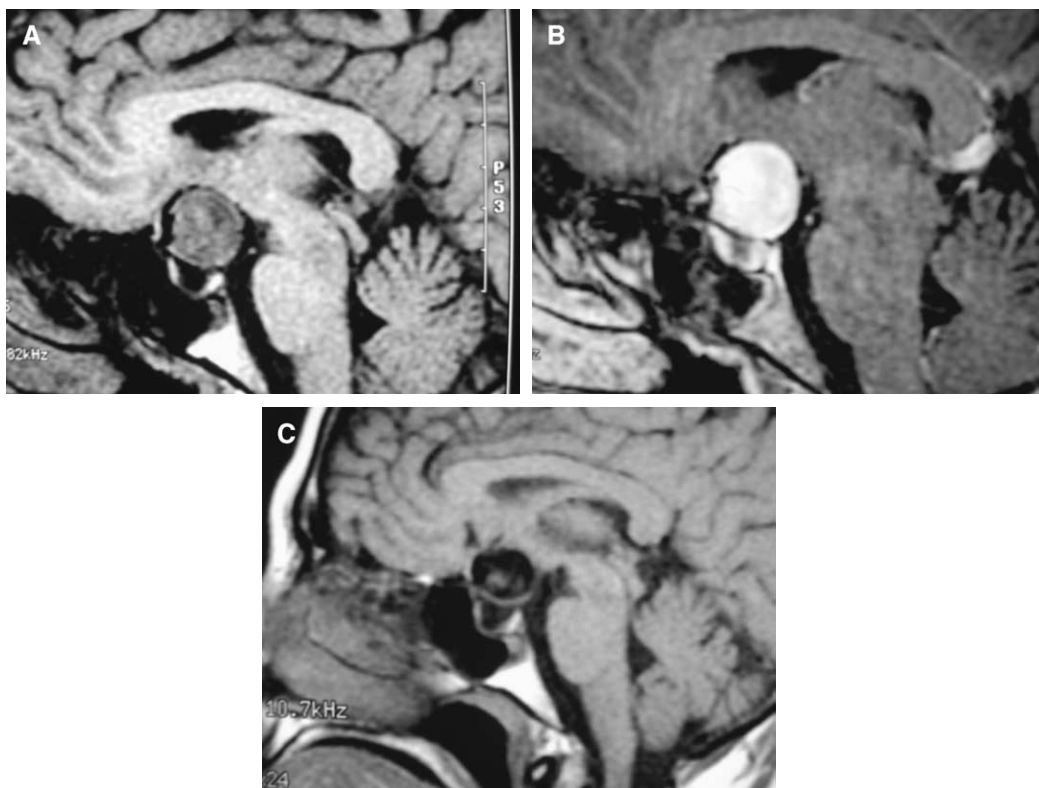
Large suprasellar aneurysm, mimicking neoplasm. (A) Sagittal T1-weighted image using the spoiled grass gradient recalled acquisition in the steady state technique shows a hypointense mass in the suprasellar region. (B) Sagittal T1-weighted image shows an intense enhancing mass in the suprasellar region. (C) Sagittal T1-weighted image using the spin-echo technique clearly shows the signal void within the aneurysm.
